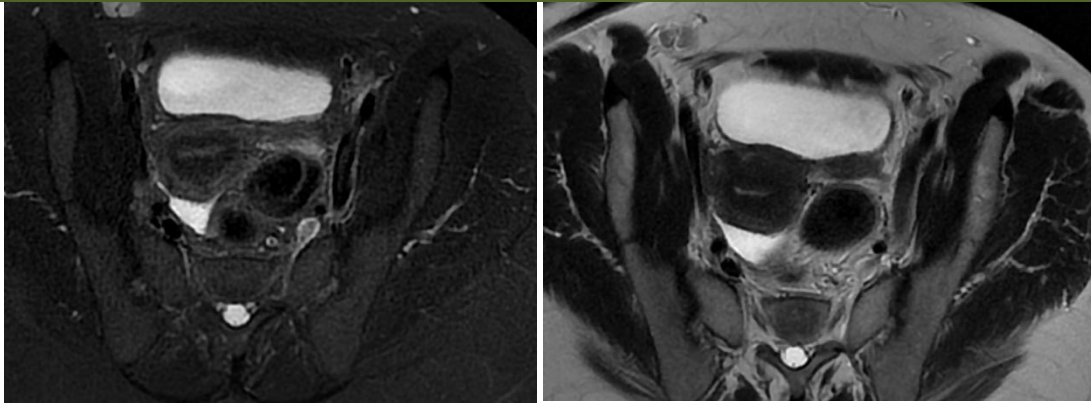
Cross sections of the pelvic MRI showing an appearance of Napoth cysts in the uterus; an effusion of moderate abundance with bilateral inguinal lymphadenopathy
